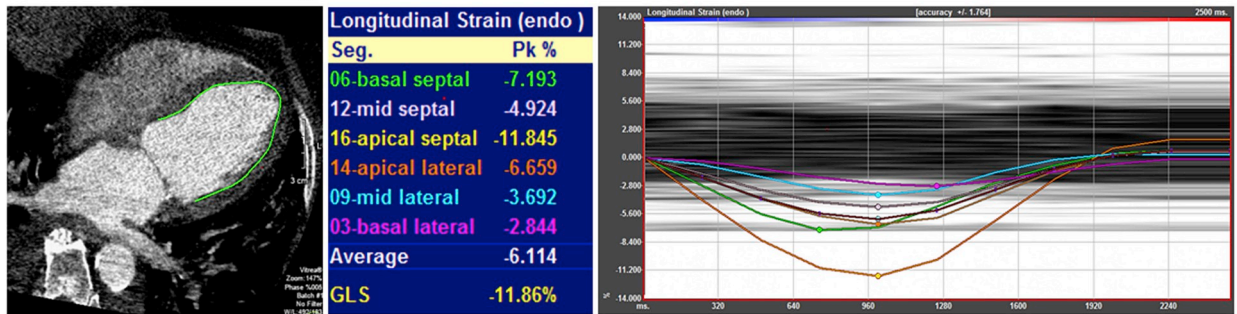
Panel A – GLS in 4 chamber by TTE. Panel B – GLS in 4 chamber by CTA. CTA, computed tomography angiography; GLS, global longitudinal strain; TTE, transthoracic echocardiography.³⁹
